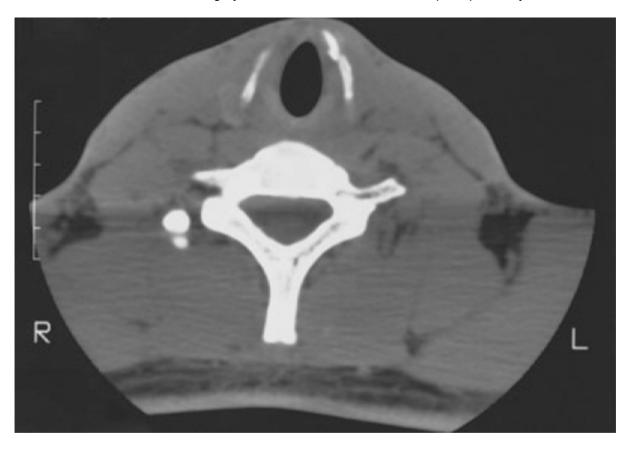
Minimal displacement of the thyroid cartilage demonstrated on computed tomography scan may not require open reduction, but the mucosa must be carefully evaluated before nonoperative intervention can be deemed satisfactory.
